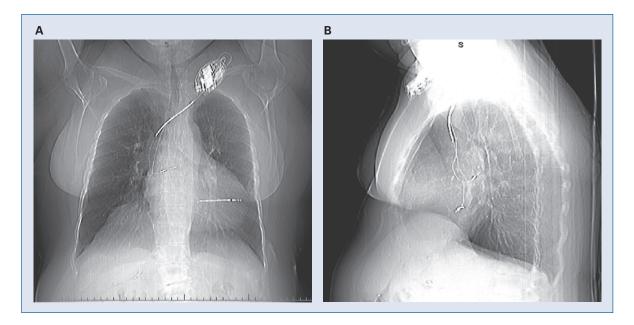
A. Chest X-ray: posteroanterior view; B. Chest X-ray: lateral view.
